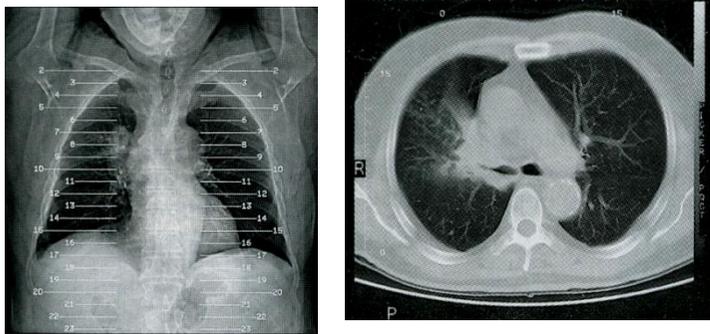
Bronchial carcinoma, revealed on chest X-ray and confirmed by CT scan. The reference chest X-ray (2) shows a mass adjacent to the upper right hilum. The transverse CT scan at level 9 (3) shows a tumour surrounding and narrowing the right upper lobe bronchus, with obstructive changes peripheral to it. Note the incidental presence of calcification in the wall of the descending aorta.
